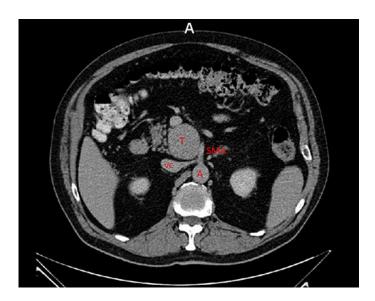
The CT image depicts a soft density lesion adjacent to the root of the SMA and pancreatic head. T = Tumor; A =aorta; VC = vena cava.
